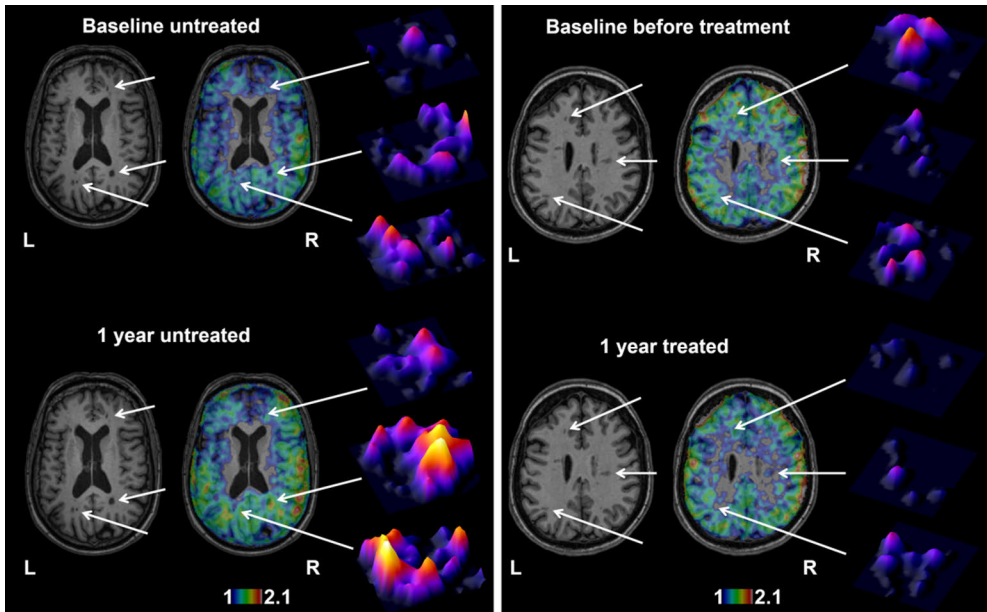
Visual demonstration of the change in microglial activation in an individual untreated SPMS patient and a natalizumab-treated RRMS patient. (A) Axial view of T1 MRI image and respective ^{11}C -PK11195 TSPO-PET image overlaid with the T1 image at baseline (top row) and after one year (bottom row) in an untreated 53-year-old woman with a disease duration of 29 years and EDSS score of 6.0 at baseline and 6.5 at follow-up. White arrows point to the perilesional ^{11}C -PK11195 uptake of chronic active T1-hypointense lesions that increases during the follow-up. The increased perilesional ^{11}C -PK11195 uptake can also be visualized using surface plots of the chosen lesions (on the right). (B) Axial view of T1 MRI image and respective ^{11}C -PK11195 TSPO-PET image overlaid with the T1 image at baseline (top row) and after one year (bottom row) of a natalizumab-treated 46-year-old woman with a disease duration of 7.6 years and EDSS score of 2. The perilesional ^{11}C -PK11195 uptake decreases during the follow-up (white arrows). The surface plots visualize the decreased microglial activation in the perilesional area of the chosen lesions (on the right). EDSS = Expanded Disability Status Scale; RRMS = relapsing-remitting MS; SPMS = secondary progressive MS; TSPO = translocator protein. Reprinted with the permission from Study II.
